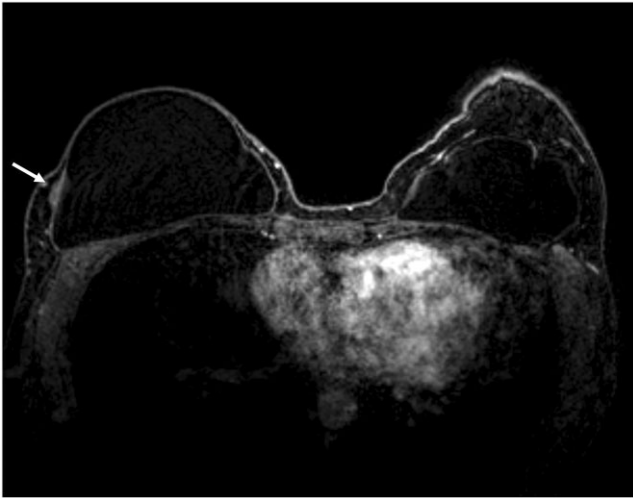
Acellular dermal matrix (ADM) at DCE-MRI. MRI view of focal pericapsular thickening without suspicious contrast enhancement in nipple-sparing mastectomy with human ADM implant-breast reconstruction.
